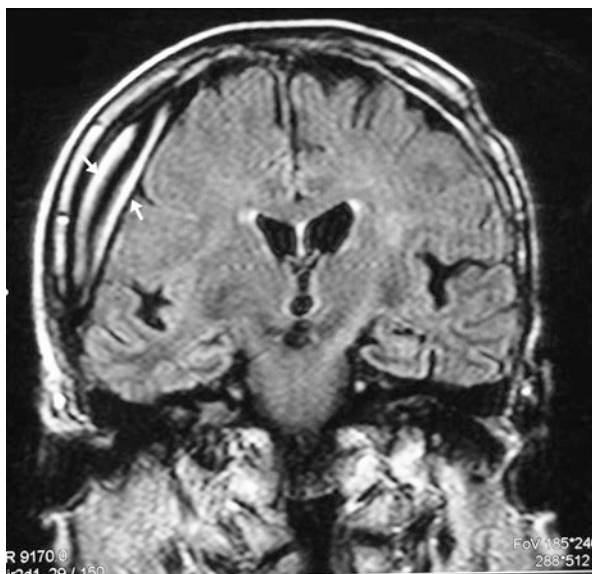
Preoperative T1-weighted contrast-enhanced MRI showing a thickened inner and outer membrane within the right hemispheric organized CSDH (white arrows)
